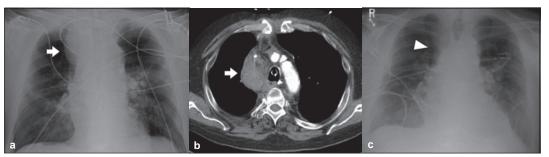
a. Anteroposterior chest X-ray at admission showing a nodular opacity near the superior vena cava (arrow); b. Computed tomography axial chest scan showing mediastinal haematoma along the right side of the trachea, inferior to the right subclavian vein (arrow); c. Anteroposterior chest X-ray at a subsequent admission showing resolution of the haematoma (arrowhead).
